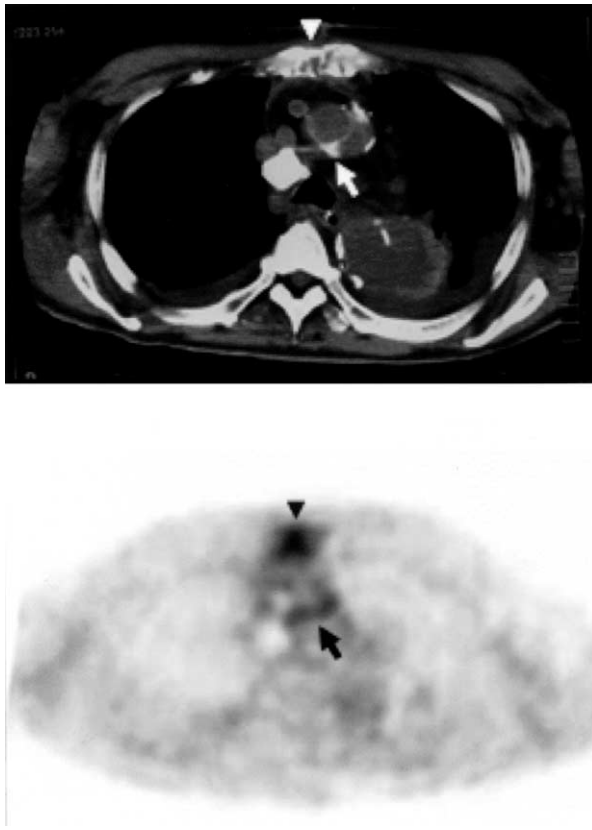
Example of true-positive findings on computed tomography (CT) and fluorodeoxyglucose (FDG) positron emission tomography in a patient with graft infection. The patient had undergone total aortic arch replacement 4 months before the imaging examinations. Focal FDG accumulation in the graft (black arrows) is accompanied by fluid collection and extraluminal air on the enhanced CT image (white arrows).
